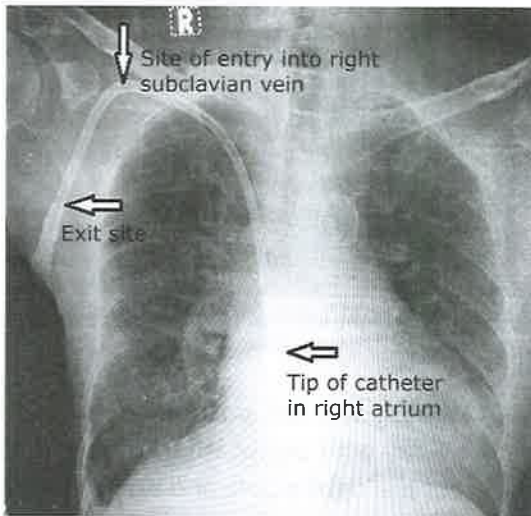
X-ray showing Permcath in right subclavian vein.
